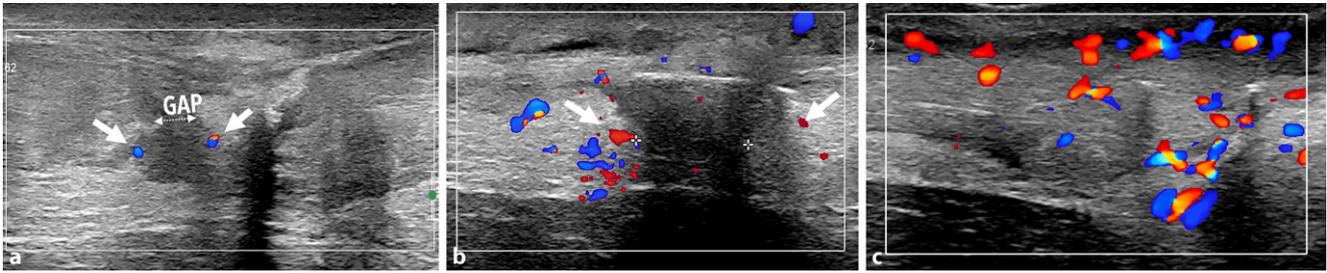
▲ Longitudinal view with color-coded Doppler US shows low vascular flow at the margins of the tendon stumps (*arrows*) at 15 days postoperatively (a) and a marked increase in vascular flow at the stump margins (*arrows*) at 1 month (b) and 2 months (c) post-surgery
